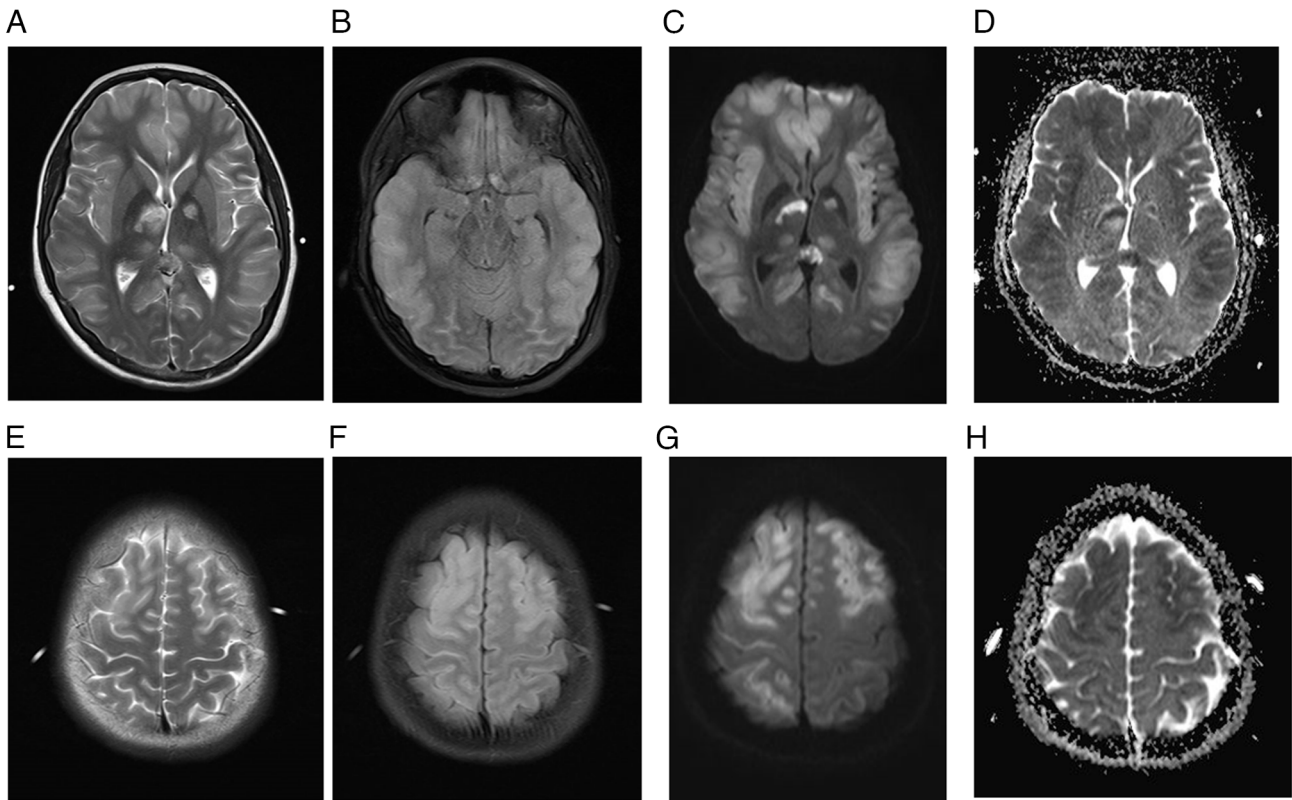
Follow-up MRI brain scan for case 4 after 10 days. (A) T2-weighted MRI, (B) FLAIR, (C) diffusion-weighted imaging and (D) apparent diffusion coefficient map demonstrating interval stability of symmetric cortical swelling, with persistent high T2 and FLAIR signal intensities involving the bilateral insular cortex, frontal lobes, temporal lobes and bilateral cingulate gyri. Regression of diffusion restriction suggests interval evolution of intraparenchymal changes associated with acute hyperammonemic hepatic encephalopathy. Interval regression of high T2 and FLAIR signal intensities, and diffusion restriction in the right anterior thalamus, left globus pallidus and splenium of the corpus callosum, indicate subacute evolution of the ischemic insults. MRI, magnetic resonance imaging; FLAIR, fluid attenuated inversion recovery.
